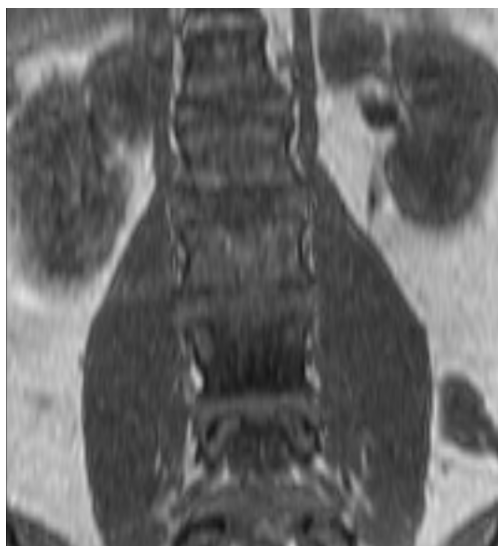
Magnetic Resonance Imaging (MRI), as seen on a coronal scan.
